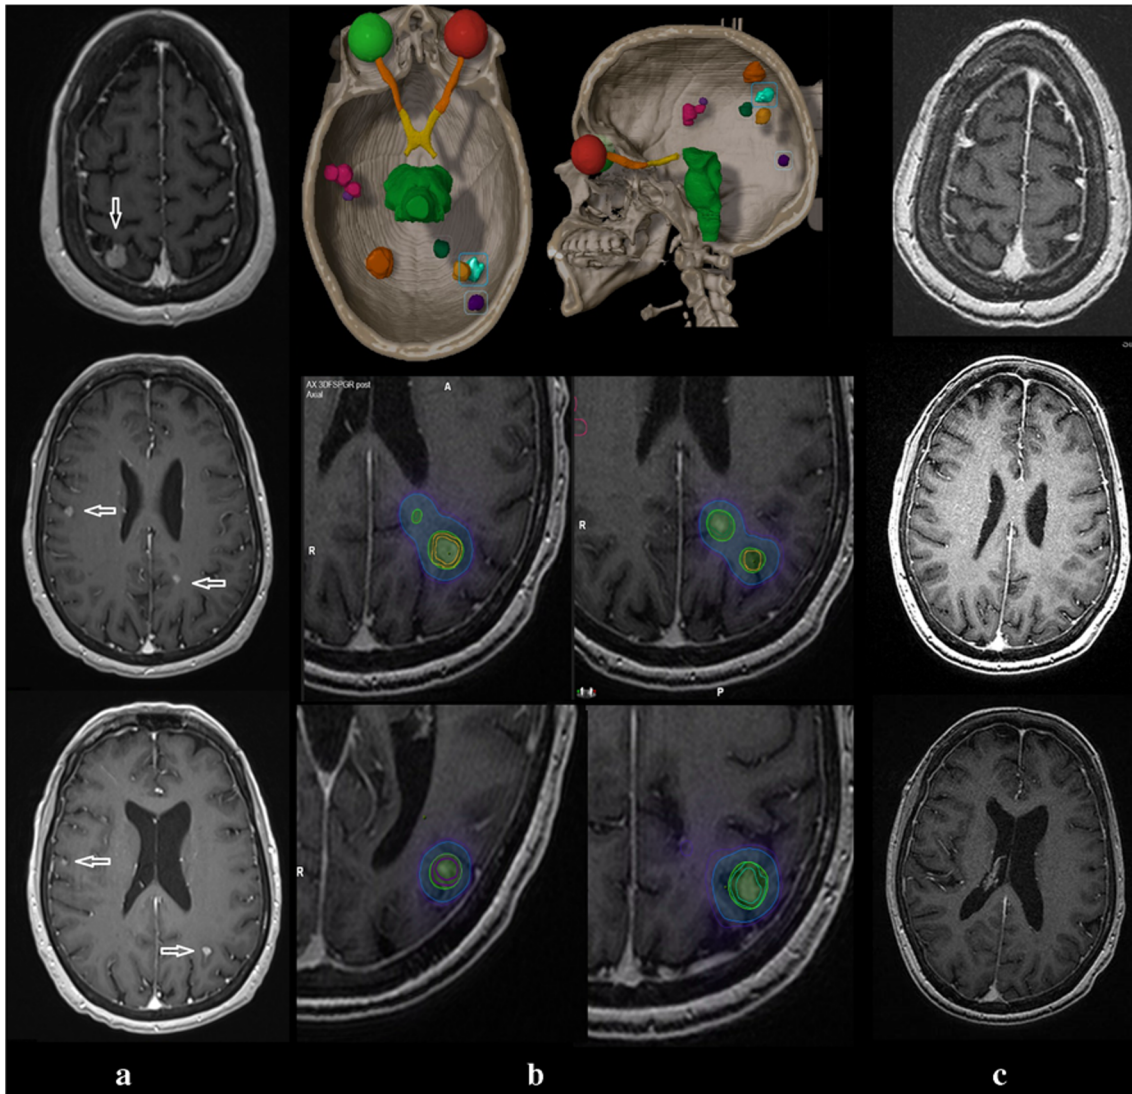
Patient with 8 melanoma brain metastases was treated with stereotactic radiosurgery (SRS). a Baseline MRI showing metastatic lesions. b SRS planning with bird’s-eye view and planning isodose lines. c Follow-up MRI after 5 months showing near complete resolution of all lesions. However, this patient developed new cerebellar lesion 8 months after initial SRS which was also treated with SRS
